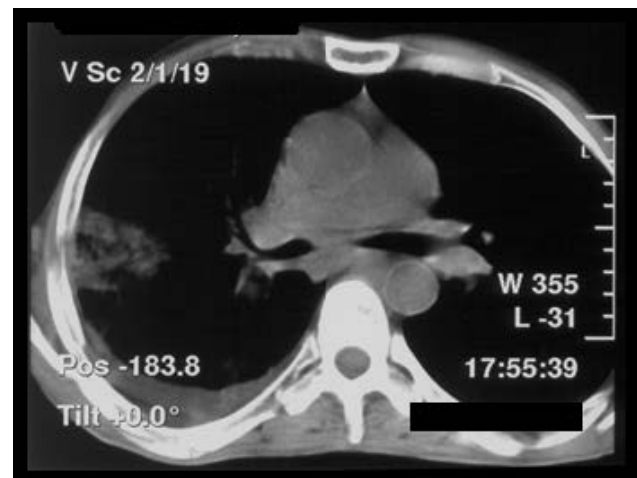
Spiral CT scan in a 53 years old male patient with acute pulmonary embolism and right lung cancer reveals a right triangular mass, in contact with pleura, nonhomogenous (pulmonary infarction); right pleural effusion
